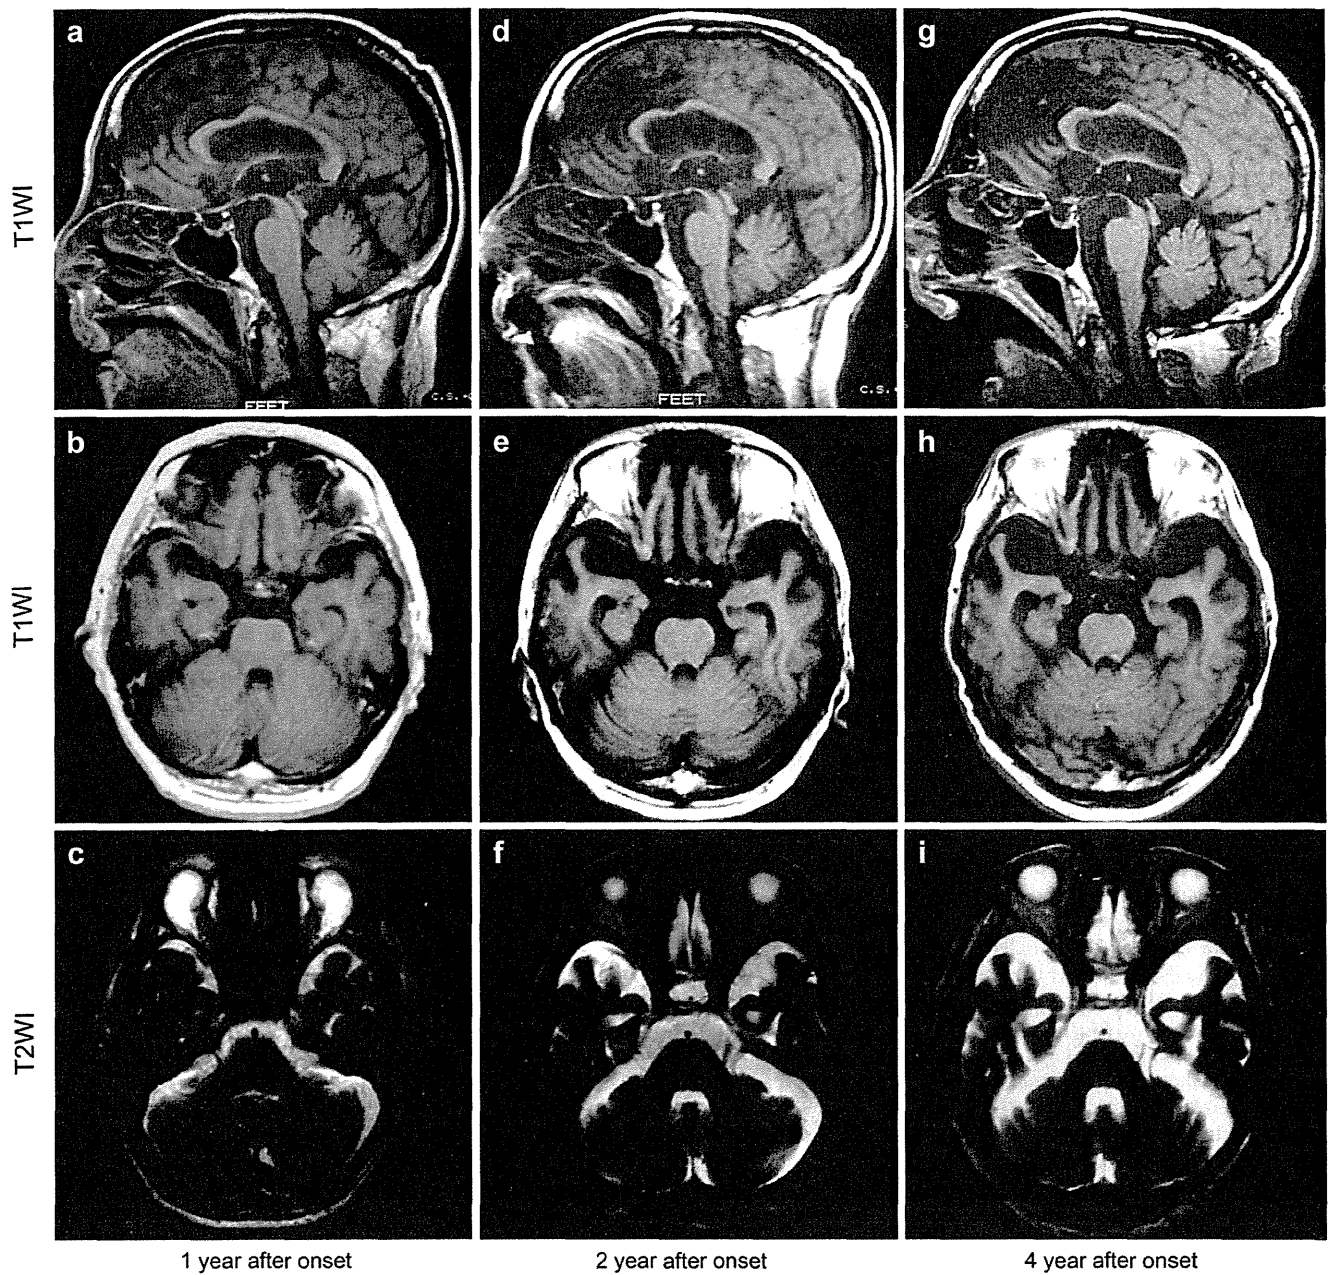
A serial MRI study in the present patient. Top panels (a, d, g), sagittal T1-weighted MRIs (T1WIs) at the level of the mesencephalic aqueduct. Middle panels (b, e, h), axial T1WIs at the level of the superior cerebellar peduncles. Lower panels (c, f, i), axial T2-weighted MRIs (T2WIs) at the level of the middle cerebellar peduncles. Serial MRIs showed atrophies of the midbrain (g), superior cerebellar peduncles (e, h), and frontal and temporal lobes (e, h), in addition to enlarged pontocerebellar cistern without overt dilatation of cerebellar fissures (i).
